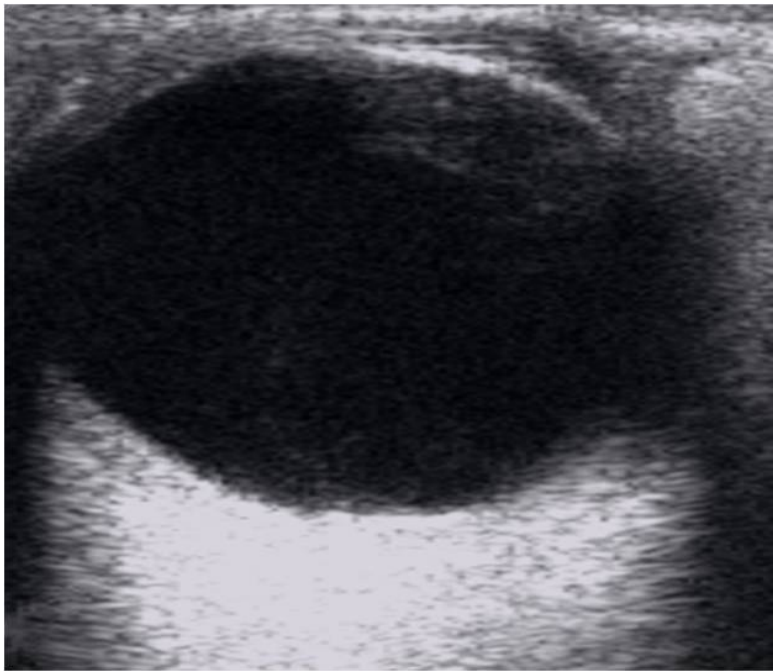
Appearance of vitreous in normal eye. On B mode ultrasound it is echo free.
